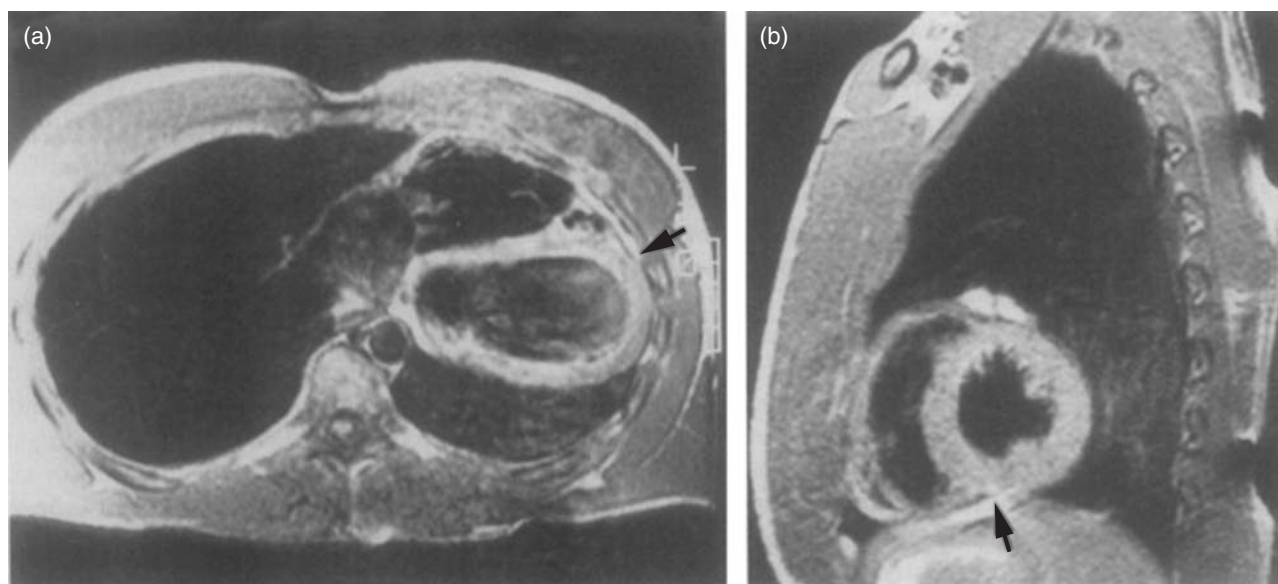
Magnetic resonance imaging scans of chest. (a) Axial scan through mid-ventricular level demonstrates pronounced leftward deviation of cardiac axis. Pericardial stripe terminates abruptly (arrow). (b) Sagittal view results in a short axis projection because of leftward deviation of heart. Note abrupt termination of pericardial stripe (arrow). *Source:* Van Son *et al.* 1993 [5]. Reproduced with permission of Elsevier.
